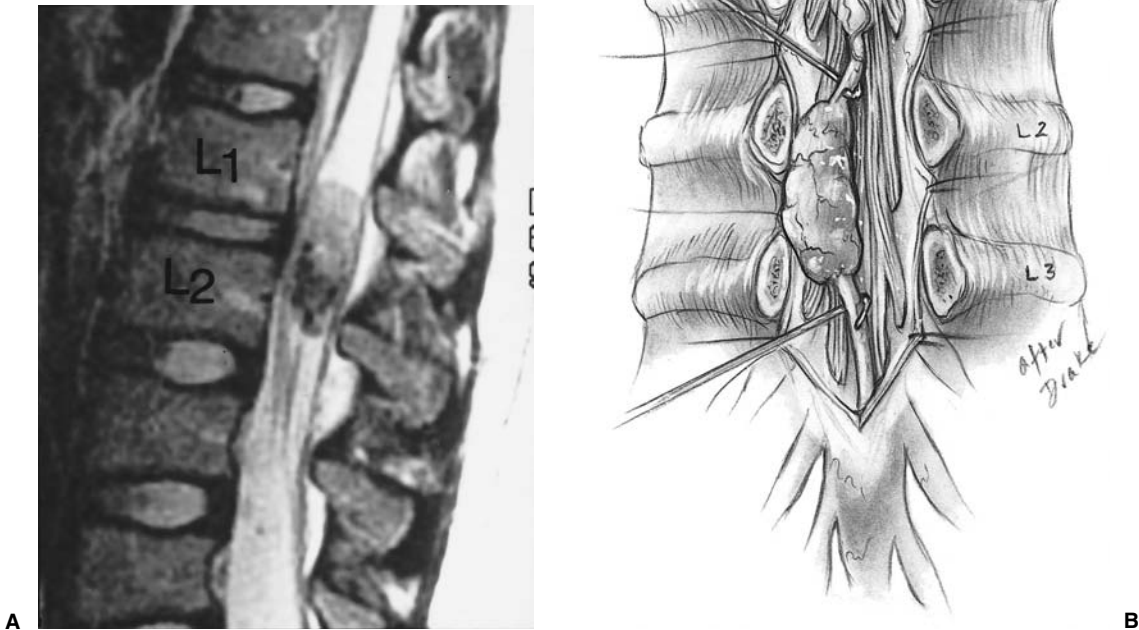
This 13-year-old boy developed an acute onset of low back and bilateral leg pain when he “plopped” himself down on a chair in a movie theater. Neurologic examination revealed no motor weakness or sensory changes. MR imaging of the spine (A) showed an
